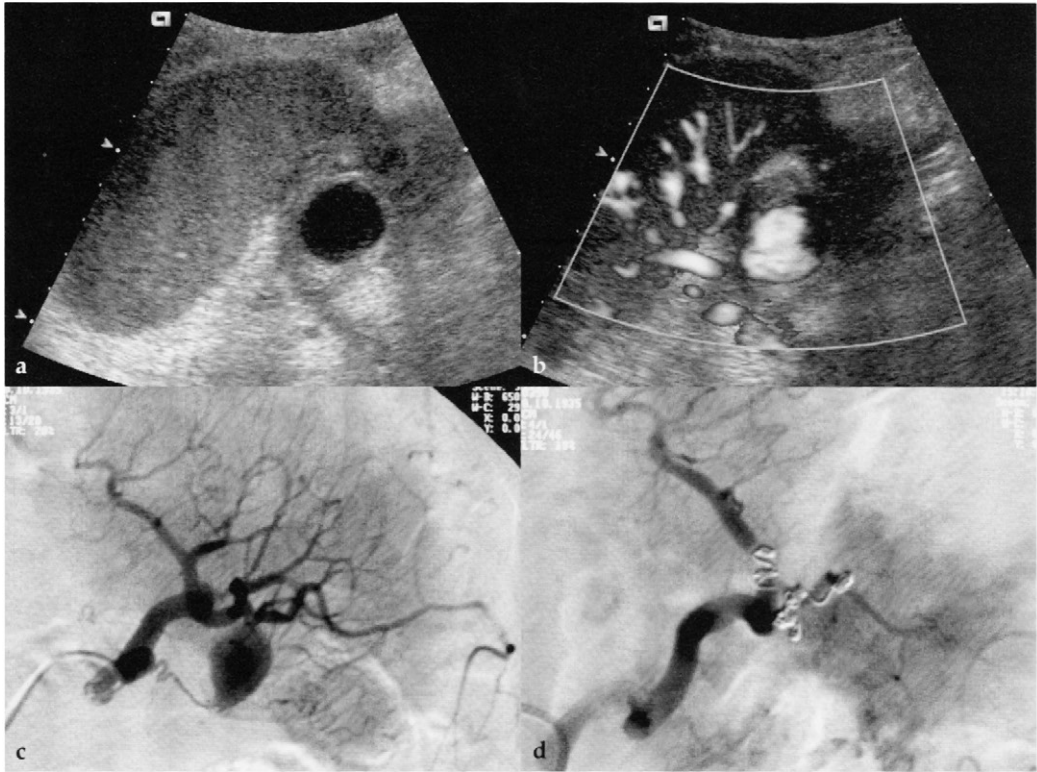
Bleeding pancreatic pseudocyst. Ultrasonography shows a fluid-filled mass (asterisk) at the level of the pancreatic tail, adjacent to the splenic hilum.
